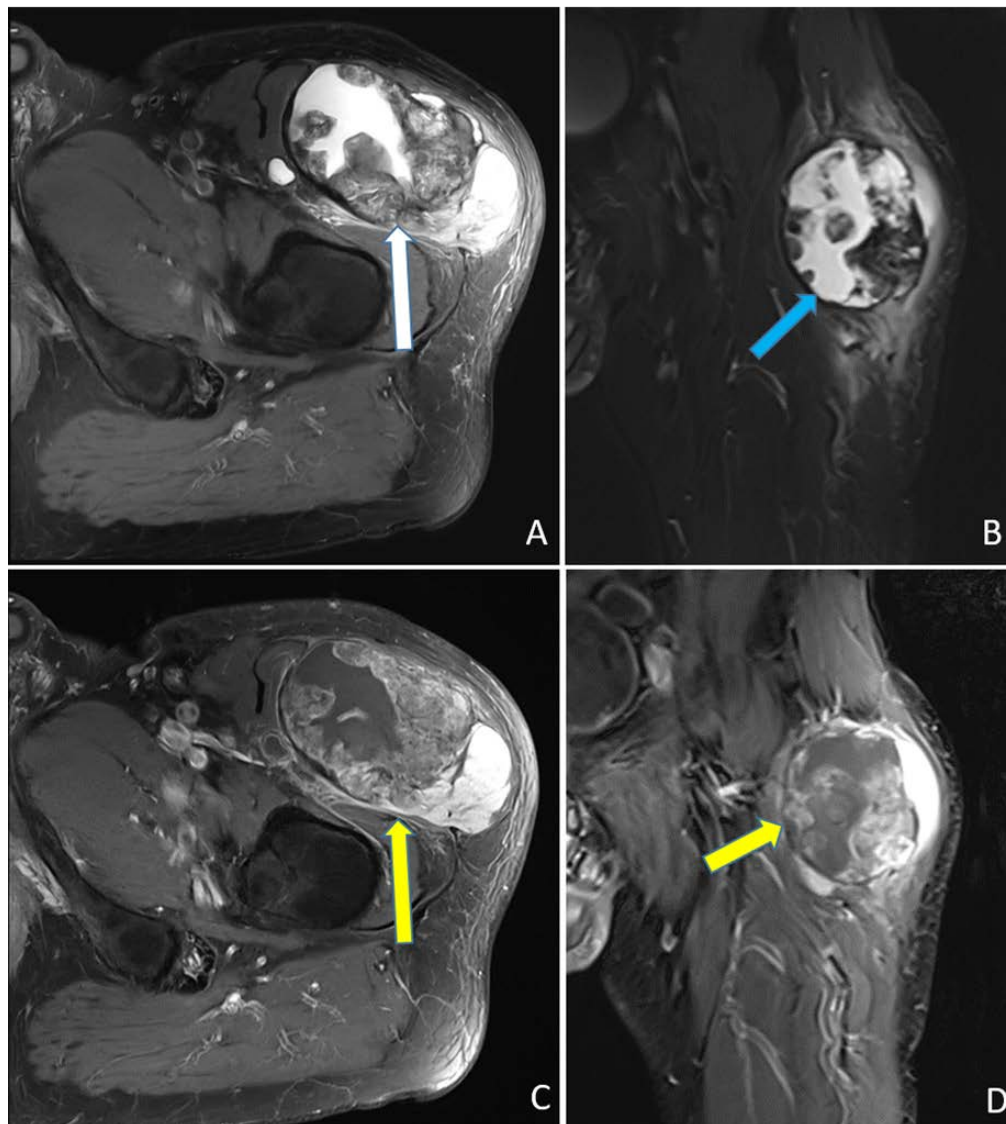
EOO in the left thigh. A (axial), B (coronal): Proton density sequence images without contrast demonstrate a 9.5 x 6.2 x 8.0 cm mass with mixed solid (yellow arrow) and liquid (blue arrow) components. C (axial), D (coronal): Contrast enhanced T1-weighted MRI images show inhomogeneous contrast uptake (yellow arrows).
